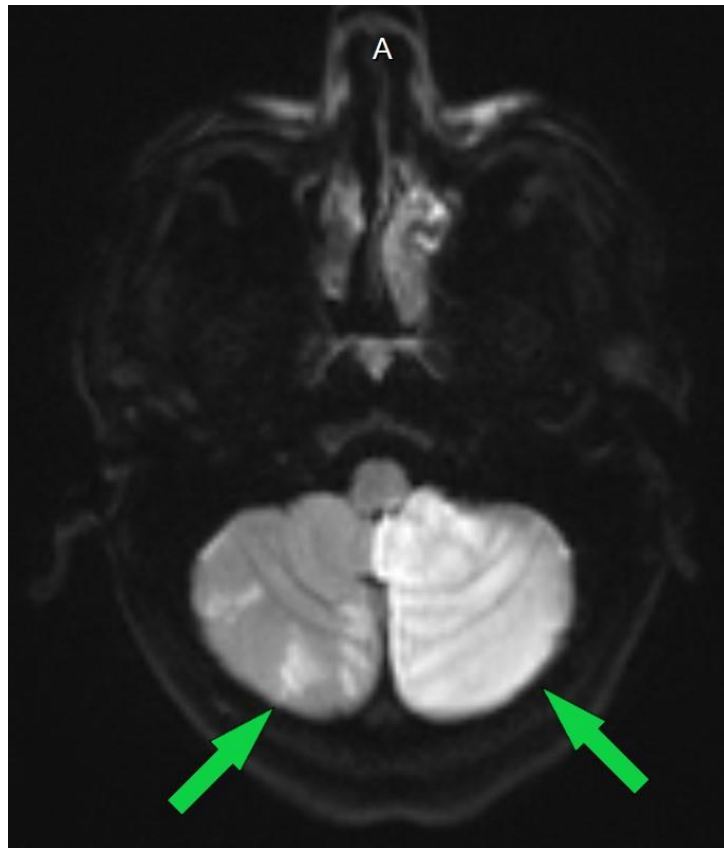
Brain MRI examination without contrast showing bilateral, left greater than right, cerebellar infarctions. (green arrows)
